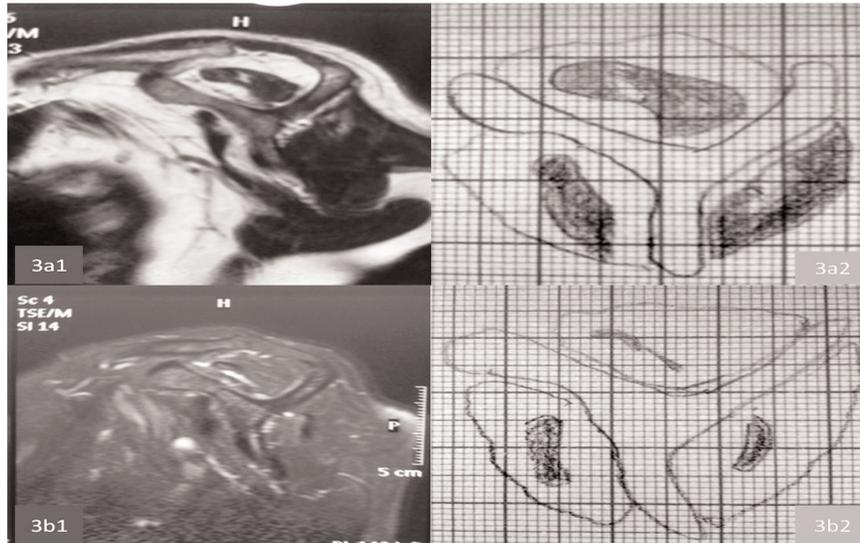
T1-weighted scapular-Y MRI of the same patient at the initial presentation (a), and T2-weighted scapular-Y MRI at the final examination (b). Note that phase 3 fatty degeneration of supraspinatus and subscapularis muscles and phase 2 fatty degeneration of infraspinatus progressed to phase 4.
